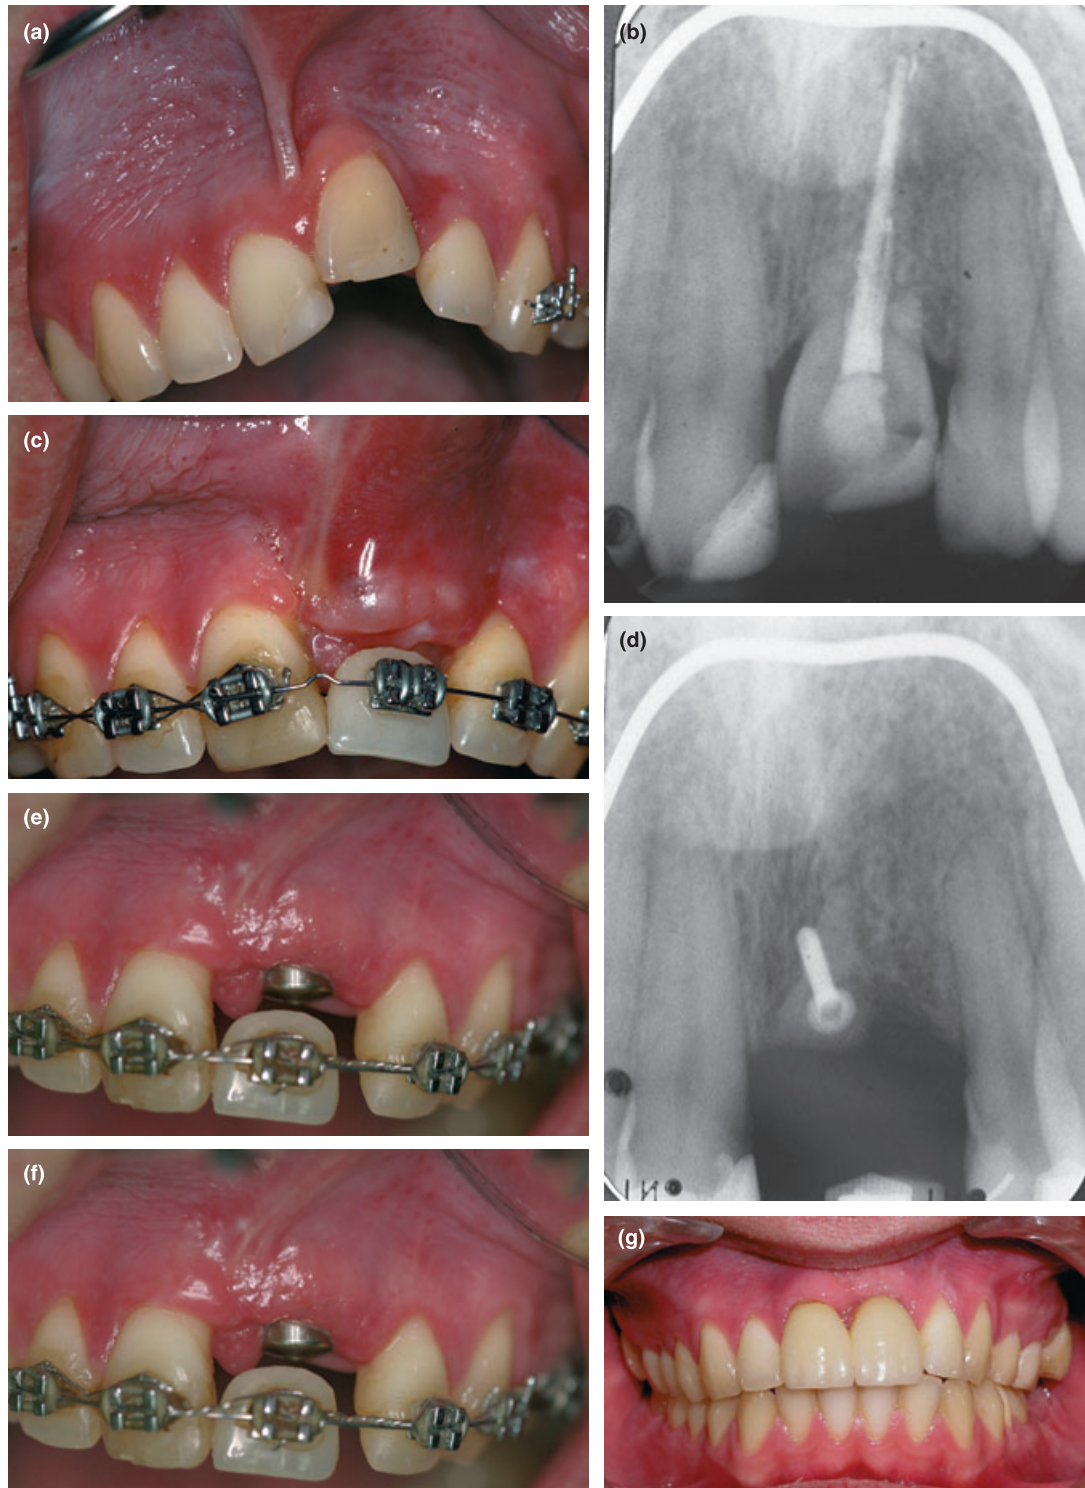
(a) Clinical view of ankylosis of the upper left incisor; (b) radiography; (c,d) orthodontic alignment of the root and bone and bone grafting after tooth extraction; (e) 1 month after abutment connection; (f) radiography after abutment connection; (g) clinical view after placement of the screw retained crown.
